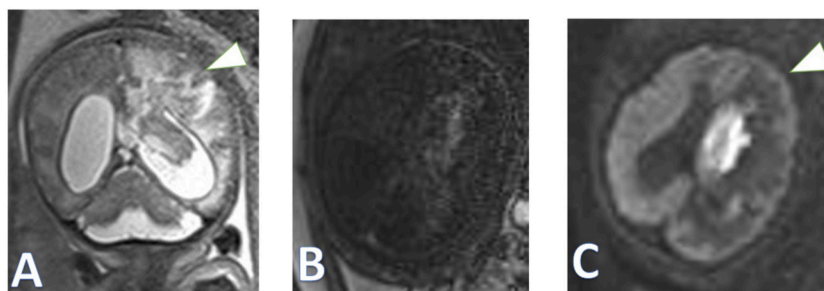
A 37-GW singleton pregnancy. A giant GM-IVH haematoma had shifted the midline a little on T2WI (A) and T1WI (A). The volume of the involved cerebral parenchyma decreased more than on the normal side (arrowhead). This character can be seen more clearly on DWI images (C). This case also had TCS syndrome (not shown). After birth, a V-P shunting procedure at 2 months old was performed. The main symptoms included muscle weakness with normal defecation function.
